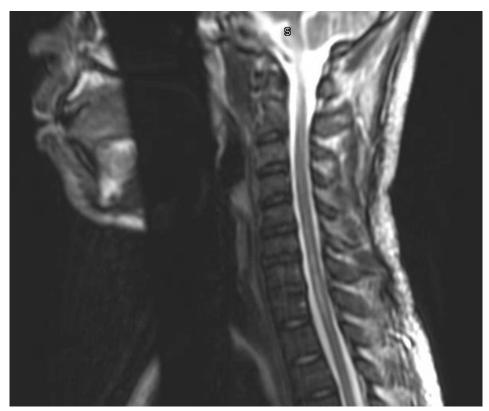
MRI Cervical and thoracic spine sagittal T2 Interval improvement in cord edema from C2-T2 and resolution of ventral epidural lesion.
